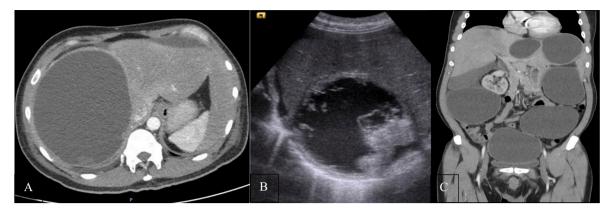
Initial CT scan showing huge right hepatic lobe cyst (A). Ultrasonographic findings of complex hepatic cysts 2 years after initial surgery (B). CT scan findings of recurrent, multiple abdominopelvic cysts after 4 years and 2 laparoscopic surgeries (C).
